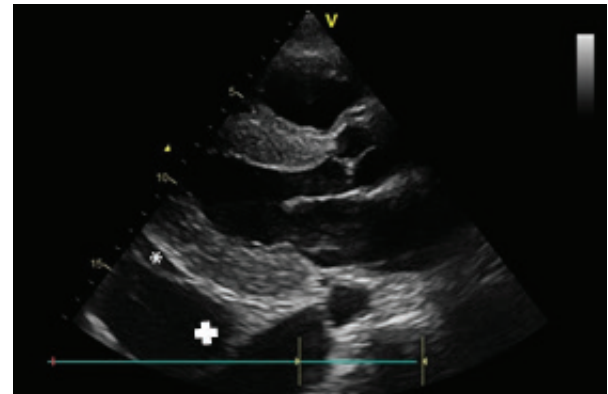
Parasternal long-axis view showing the speckled appearance of the myocardium, mild pericardial effusion (white star) and a large pleural effusion (white cross).
